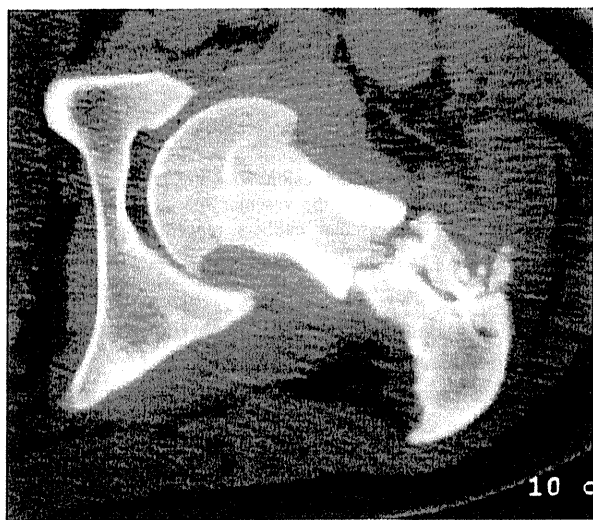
Computed tomography (CT) images showed a dense area of soft tissue with scalloping of the femoral neck. Irregular osteolytic and sclerotic changes with bony fragments were present at the trochanteric region
